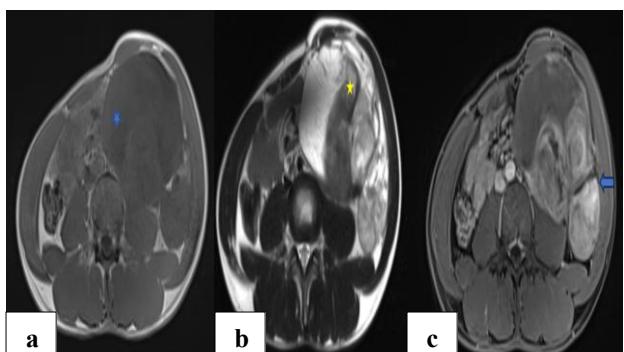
MRI abdomen axial images show (a) T1WI axial image shows a well-defined hypointense mass in the retroperitoneum on the left side crossing the midline (blue asterisk), (b) T2WI axial image shows a heterogeneously hyperintense mass with multiple hypointense septae, giving a whorled appearance. (yellow asterisk), and (c) post-contrast T1WI shows enhancement of solid components (blue arrow).
